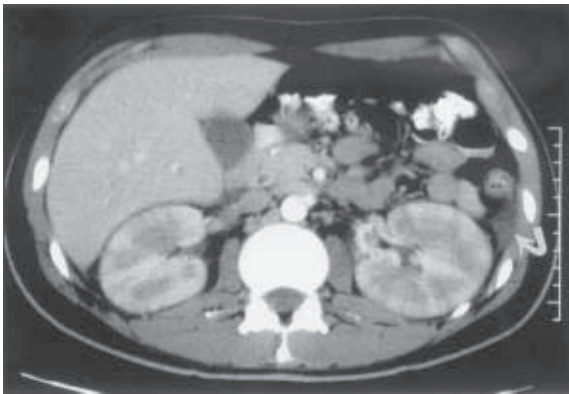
Pyelonephritis. CT shows streaky and wedge-like areas of decreased parenchyma enhancement. Some adjacent inflammatory oedema of fat is best seen anterolateral to left kidney (curved arrow).
